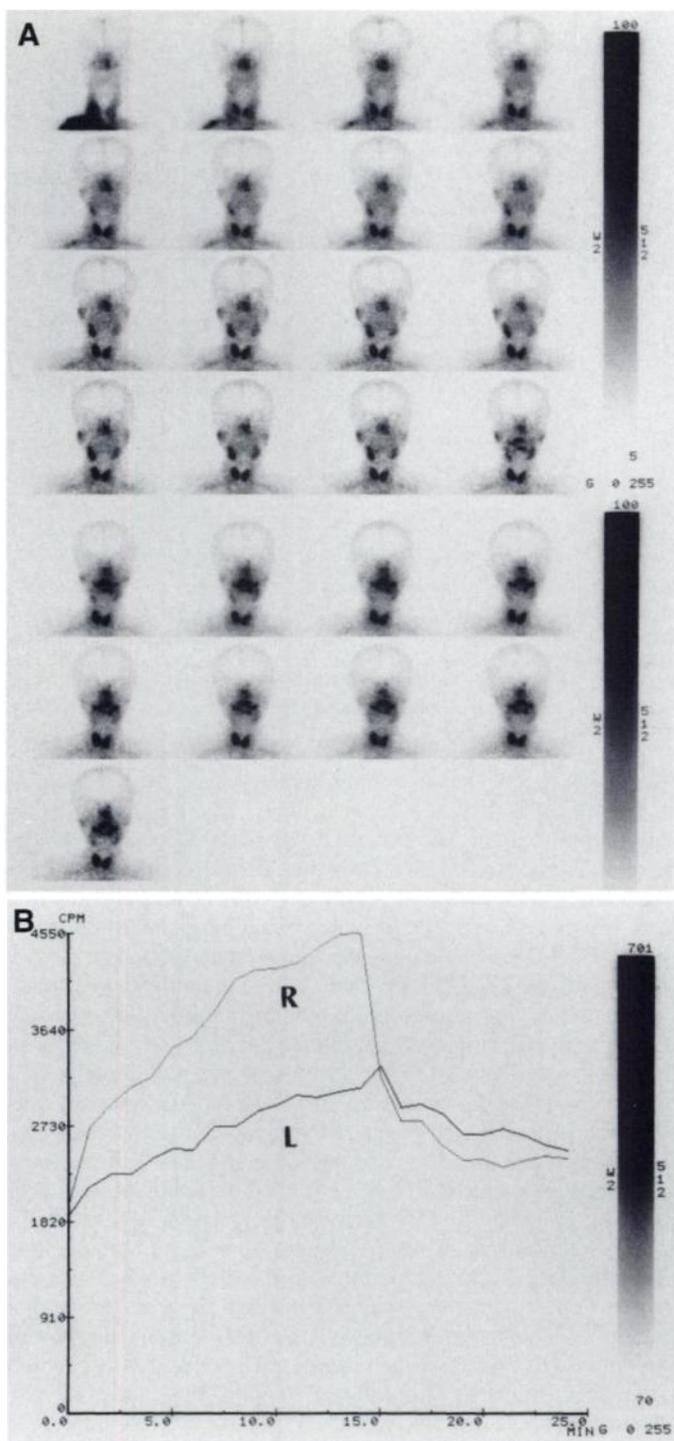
Salivary scintigraphy performed 6 days after the onset of left complete facial paralysis (Bell's palsy) in a 53-yr-old woman. Sequential 1-min images are shown from the upper left to the lower right. Stimulation of salivary secretion was performed at 15 min after administration of radionuclide (end of the 15th imaging). (A) Poor visualization and poor stimulatory secretion of the left submandibular gland were observed. (B) Time-activity curve of the submandibular gland indicated that PCR was 0.72 and WR was 0.37. Recovery of the facial paralysis was incomplete (score improved insufficiently from 0-20 at final examination). R = right submandibular gland; L = left submandibular gland.
